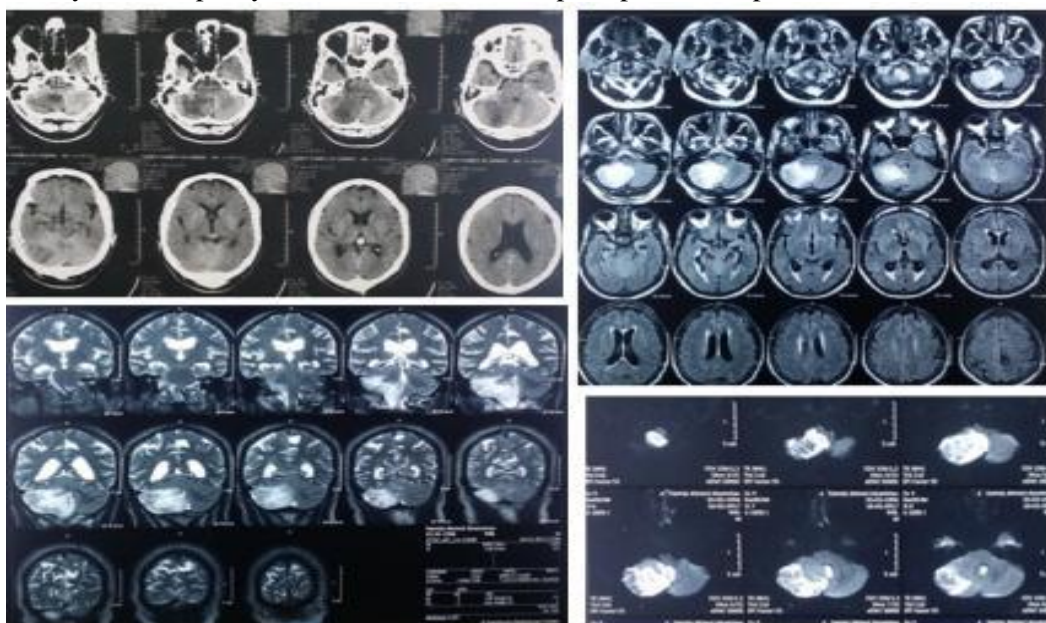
A: Preoperative CT and MRI scans of Case 1.
